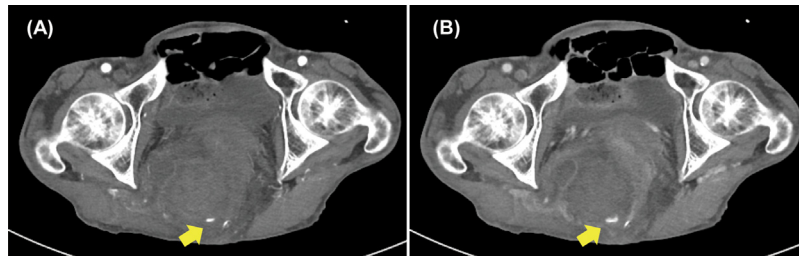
Pre-treatment axial contrast-enhanced CT images show a large subcutaneous hematoma with a small amount of active extravasation (arrow). (A) 30 s after injection of contrast medium. (B) 80 s after injection of contrast medium. CT, computed tomography
